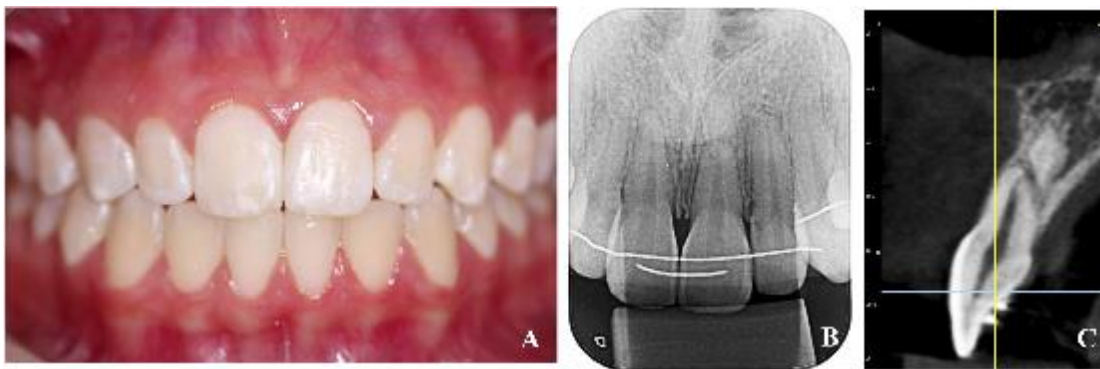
Follow-up after 2 years, A) Maxillary left central incisor without colour alteration; B) Periapical radiograph; fracture with the same extension as at the post-treatment phase; C) CBCT image, sagittal view: fracture line unchanged when compared with post-treatment images
